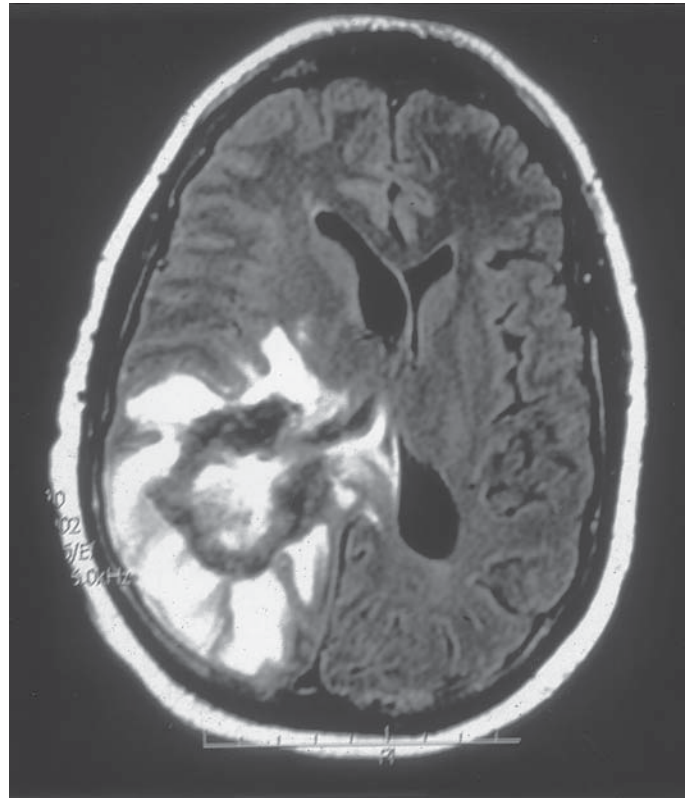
FLAIR image showing the characteristic hemorrhagic ring of an *Aspergillus* abscess.
